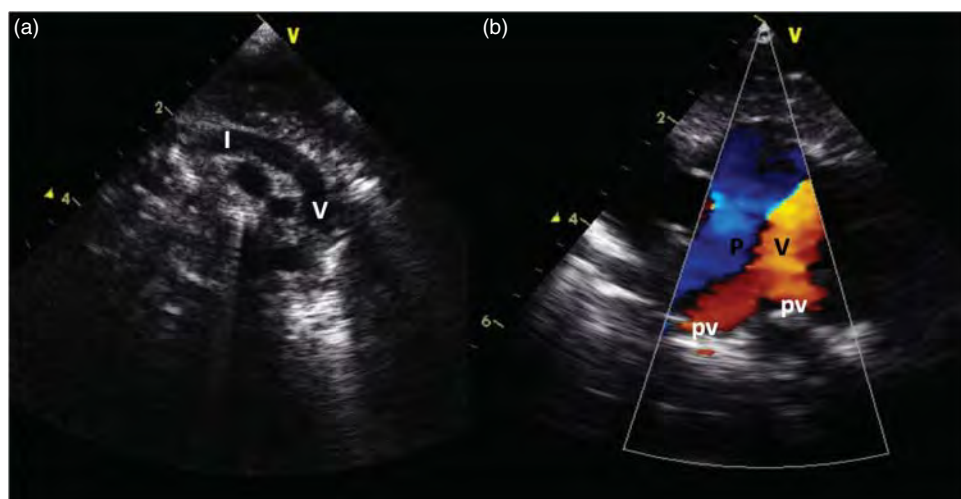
Supracardiac abnormal pulmonary drainage. Echocardiographic suprasternal views: (a) connection of the vertical vein (V) to the left innominate vein (I) forming the top part of a “snowman” figure; (b) two pulmonary veins (pv) connected to the vertical vein (V). The flow is away from the heart. The left pulmonary artery (P) is to the right.
